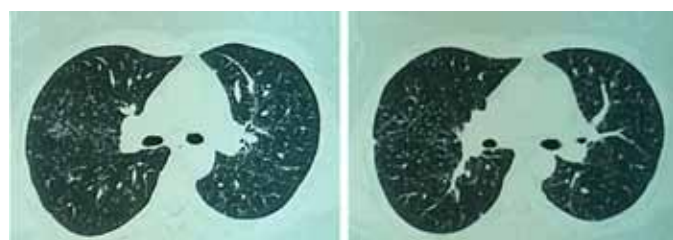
Computed tomography scan of chest revealing bilateral perilymphatic nodules in lung parenchyma.
